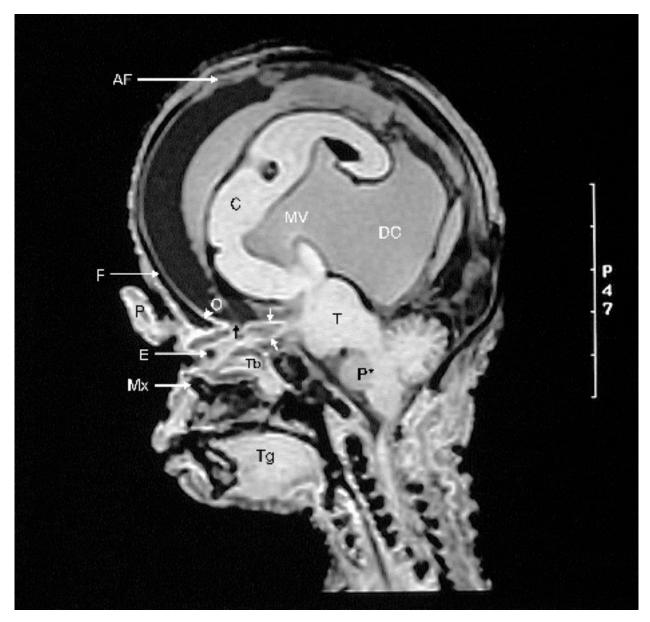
Sagittal MRI of the head and neck. Cerebrum (C) partially covers the monoventricle (MV), which is continuous with a large dorsal cyst (DC). Corpus callosum is absent. Root of proboscis (P) terminates at the ethmoid notch (black arrow), which with orbital plate (O) of frontal bone (F) and turbinates (Tb) contributes to the superior aspect of the orbit containing the primitive eye buds (E). Maxilla (Mx) does not contribute to the inferior orbit. (AF, anterior fontanelle; P*, pons; T, thalamus; Tg, tongue; white arrows, optic nerve.)
